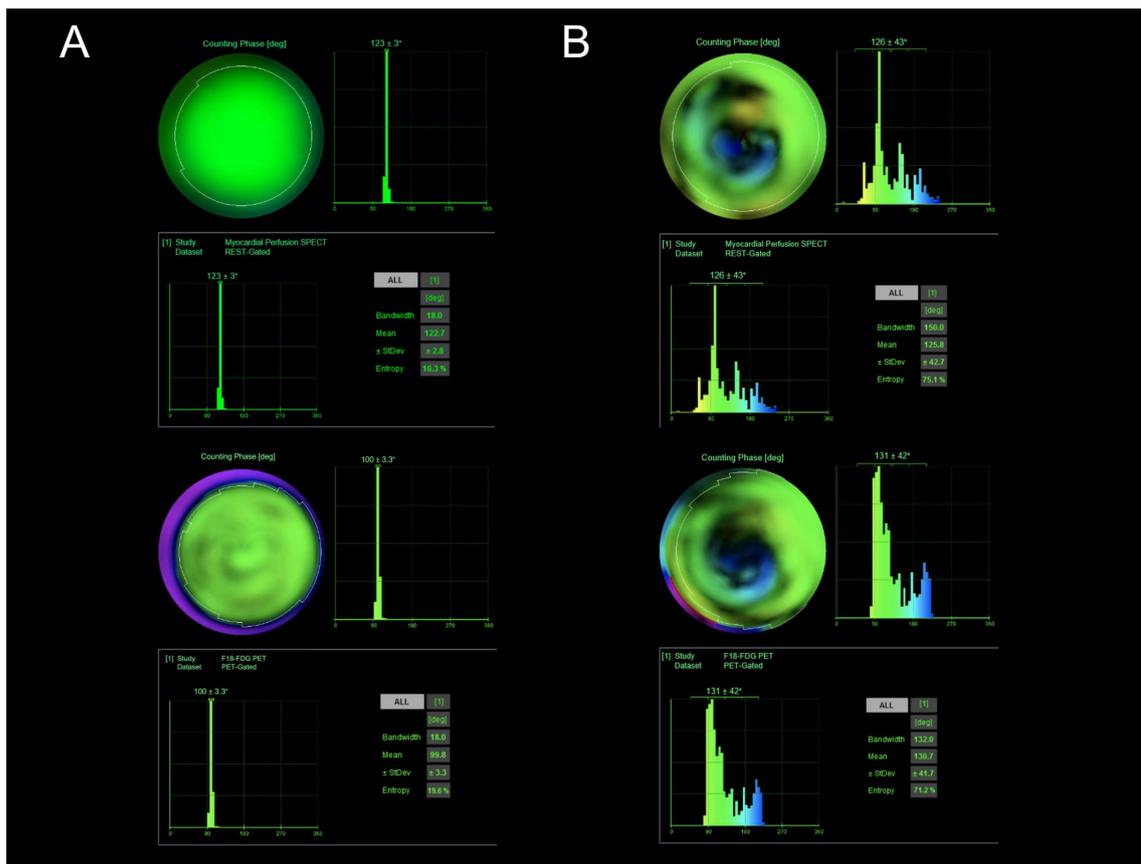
Phase analysis with QGS. Panel A shows the SPECT (upper image) and PET (lower image) phase analysis of the same patient without dyssynchrony. Panel B shows the SPECT (upper image) and PET (lower image) phase analysis of the same patient with dyssynchrony.[22]
